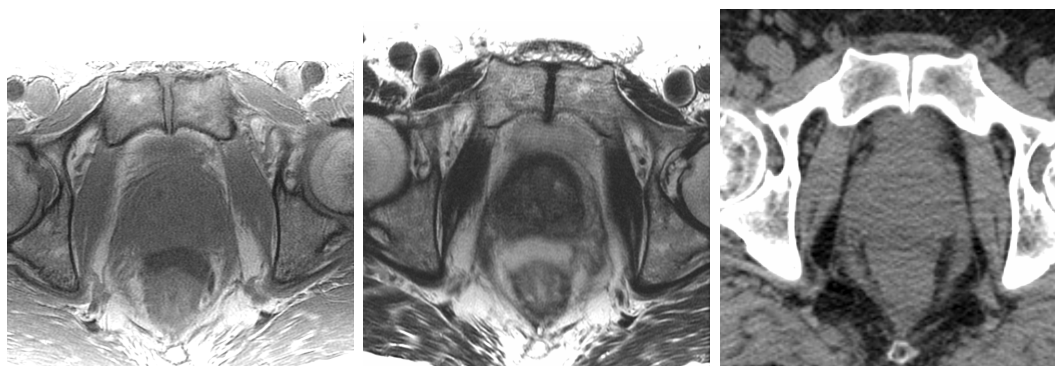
Three images of the same slice with T1 weighted MRI (left), T2 weighted MRI (middle) and with CT (right).
